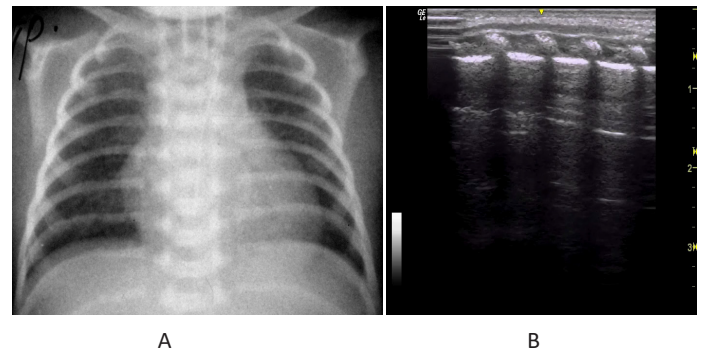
Newborn with a gestational age of 31 weeks. A. The X-ray shows a moderate enrichment of the pulmonary pattern. B. Ultrasonographically is demonstrated a normal picture in the form of the presence of A-lines (arrows).
